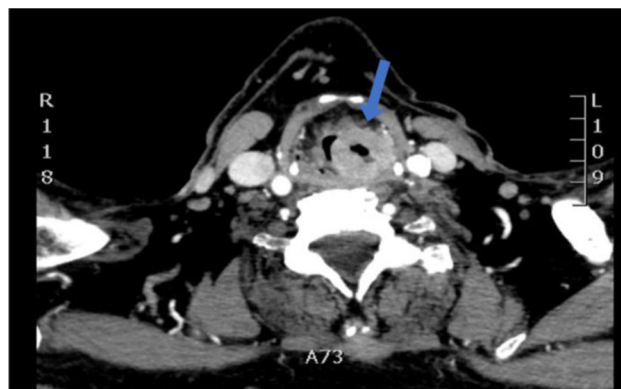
CT scan: Tumor in the left pyriform sinus (25 mm × 25 mm × 53 mm) that partially obliterates the airway, leaving a 4-mm transverse axis passage at the level of the thyroid cartilage. The arrow indicates the location of the tumor.
